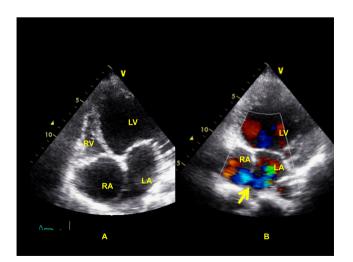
Modified apical 4-chamber view on trans-thoracic echocardiographic examination showing dilated right atrium (RA), rudimentary right ventricle (RV), dilated left ventricle (LV) (Panel A) with inter-atrial right-to-left shunting (Panel B, arrows).
